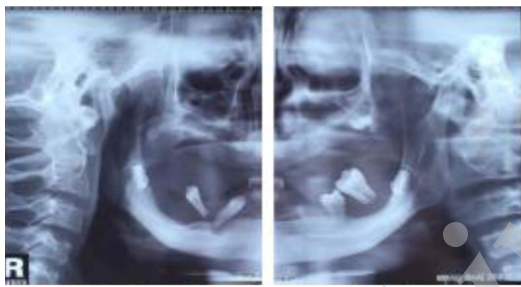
Teeth X-Ray Films of the Patient.
